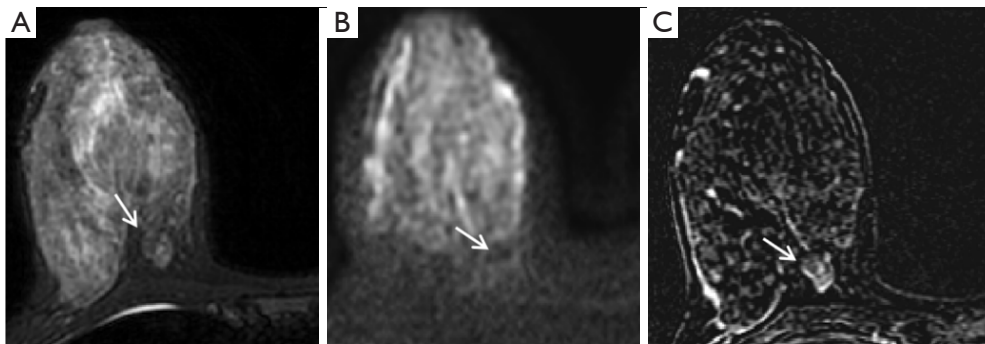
Fibroadenoma in a 41-year-old woman. The mass (white arrows) showed low signal intensity on both T2WI with fat-saturation (A) and DWI with b values of $1,000 \text{ s/mm}^2$ (B), in discordance with DWI-T2WI set in the decision rule by Kim *et al.* The lesion displayed oval shape, well-circumscribed margin, dark internal septation and persistent kinetics (C), with ADC values of $1.03 \times 10^{-3} \text{ mm}^2/\text{s}$. It was considered as benign by the decision rules by Istomin *et al.*, Zhong *et al.*, Kaiser score and BI-RADS category. T2WI, T2-weighted imaging; DWI, diffusion-weighted imaging; ADC, apparent diffusion coefficient; BI-RADS, breast imaging reporting and data system.
